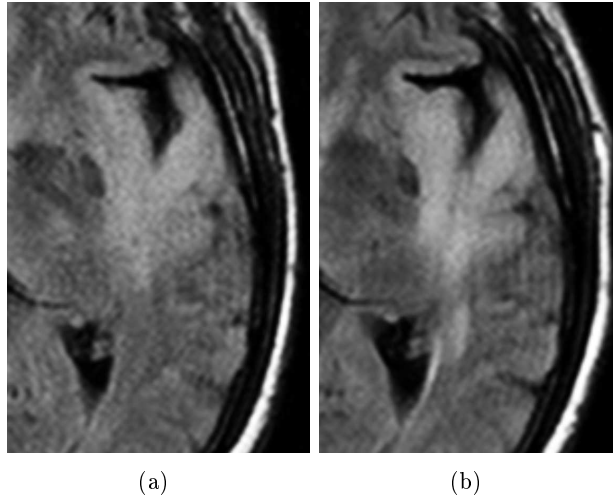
MR Flair images of a grade II astrocytoma: (a) image at the first examination (b) image at the second examination. In the anatomical MR images we observe the boundary of the visible part of the tumor rather than the tumor cell densities.
